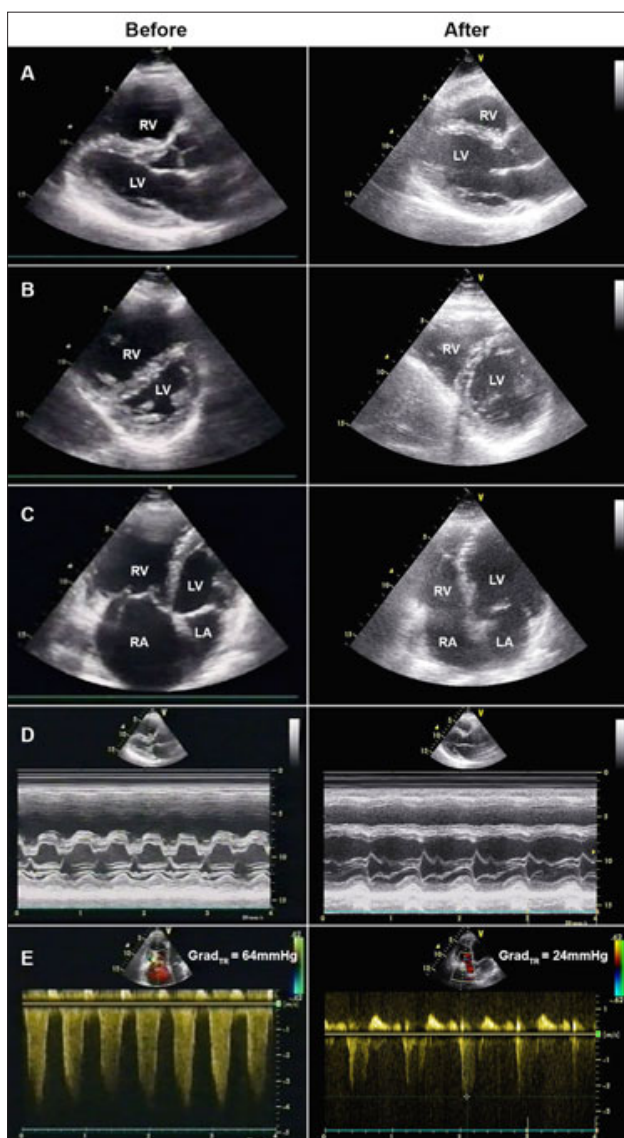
Transthoracic echocardiography. 4A–C before: Severe dilation of right ventricle (RV) and atrium (RA), displacement of interatrial septum toward right atrium, D shape of left ventricle (LV) (4B before). 4D before: Mmode echocardiography – paradox motion of interventricular septum. 4E before: Continuous Doppler echocardiography – transtricuspid regurgitation gradient of 64 mm Hg (approximation of systolic pulmonary pressure of 80–85 mm Hg). 4A–C after: total regression of right ventricular overload, of dilation of RV and RA, normalization of the shape of left ventricle (4B after). 4D after: Mmode echocardiography – normalization of interventricular septum motion. 4E after: Continuous Doppler echocardiography – transtricuspid regurgitation gradient of 24 mmHg (approximation of systolic pulmonary pressure of 35 mmHg), e.i. normalization of pulmonary pressure.
